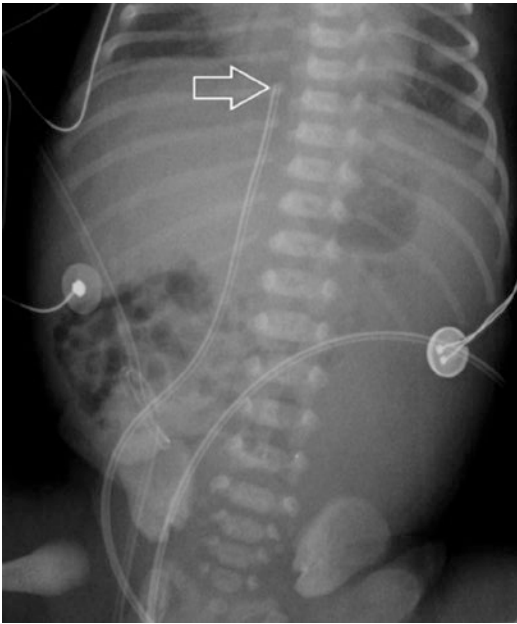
Well-positioned umbilical catheter. Plain film of the abdomen. The extremity of the UC lies just below the heart (*arrow*)
